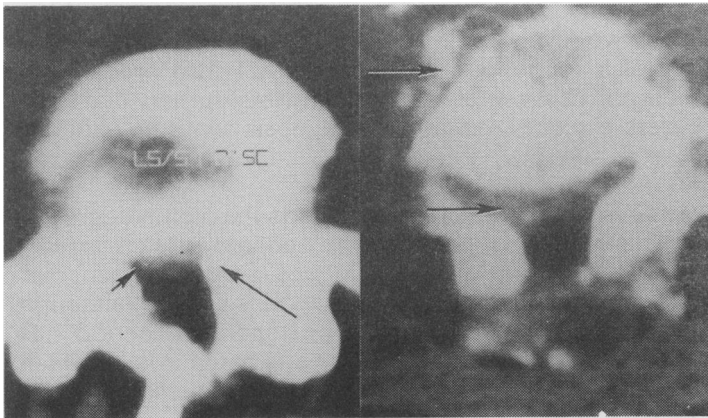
(left). Lateral recess stenosis. CT scan shows massive hypertrophy of the right interfacetal joint with encroachment on the lateral recess and nerve root (long arrow). Compare normal side (short arrow).
